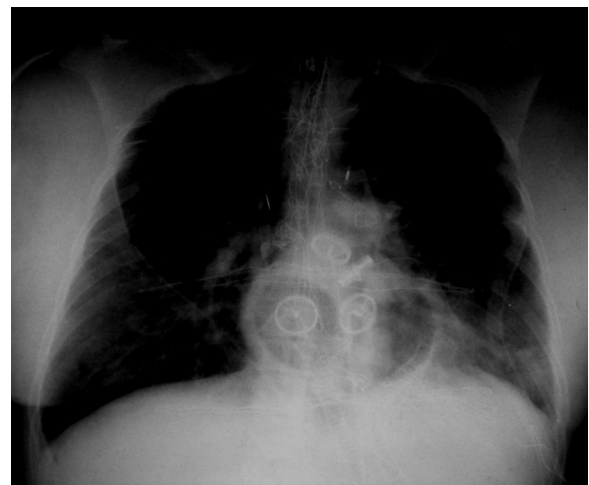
Thoracic x-ray after implantation of a CardioWest total artificial heart.
